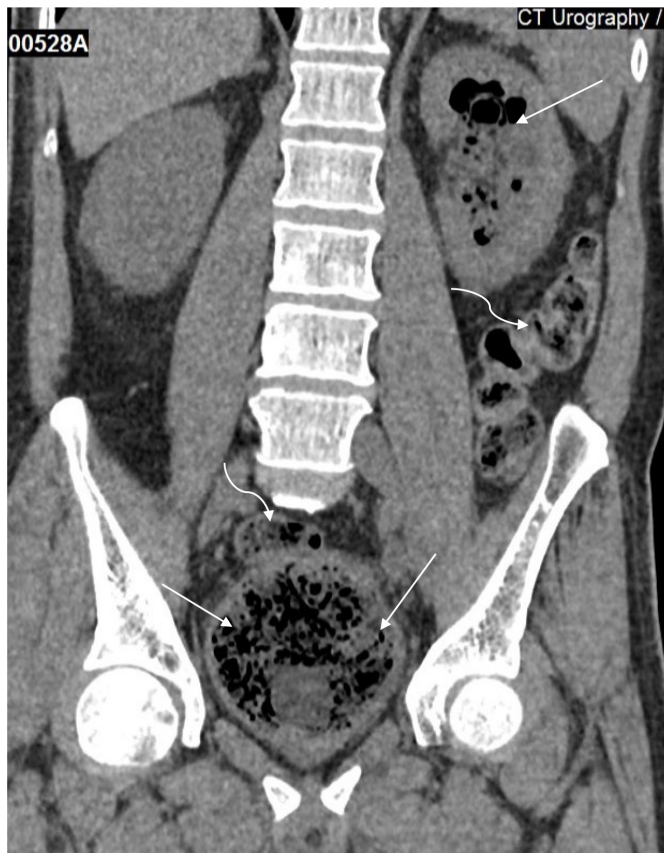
Coronal image of plain computed tomography. It showed faecaloid materials filling the urinary bladder and the left pelvicalyceal system (arrow). Note how it appears similar to the faecal materials in the sigmoid and the descending colon (curve arrow).
